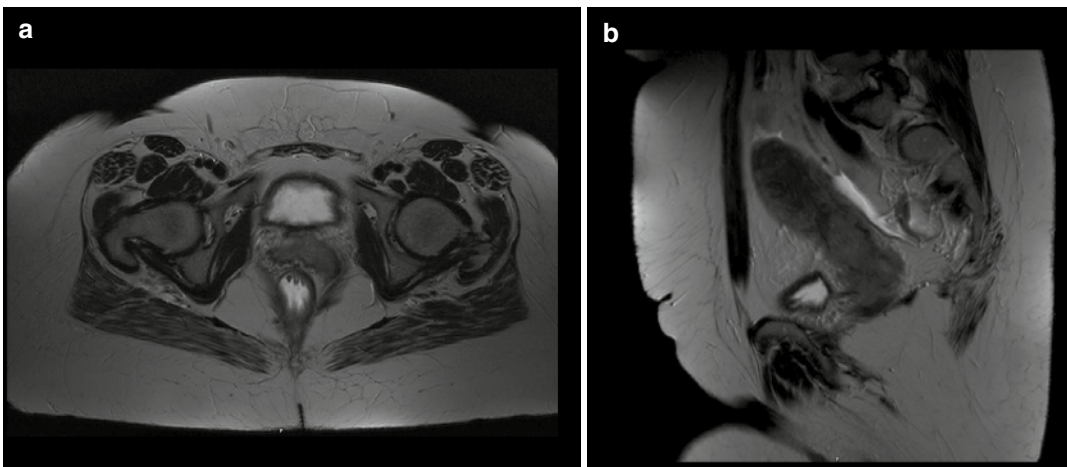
oT3b cervix carcinoma infiltrating the left mesocolpos up to the parietal endopelvic fascia. T2-weighted transverse (a) and sagittal (b) MRI scans are
